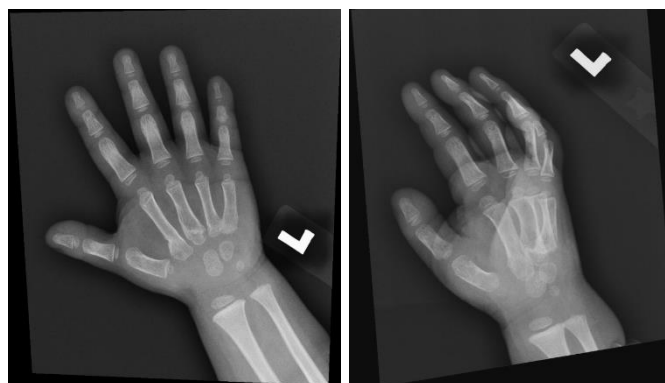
X-ray image at 10th month post-operation, showing fracture consolidated and healed with good alignment
